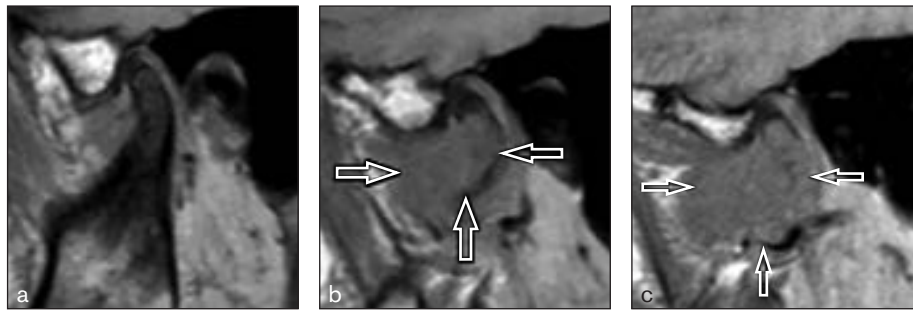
MRI sagittal slices of the right TMJ in the closed-mouth position from the lateral to medial aspects. (a) Signs of dishomogenous disc structure, with a normal disc-condyle relationship. (b) Alteration of signal within the lateral pterygoid muscle due to the presence of the condylar mass (arrows). (c) Very unspecific condylar mass (arrows), requiring diagnostic deepening with CT.
